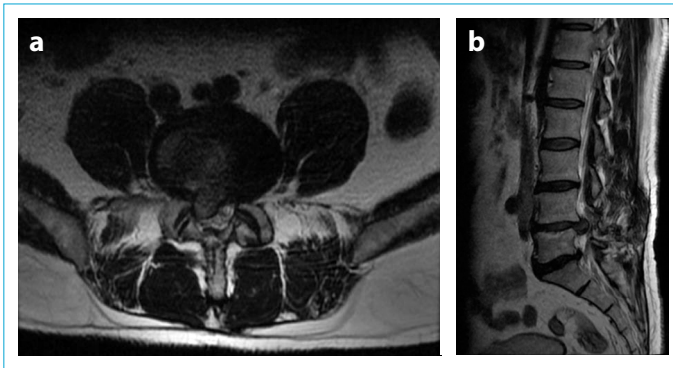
Male, 51 years old, relapsed 2 years after lumbar microdiscectomy for L4-5 right paracentral herniation. (a, b) T2 axial and sagittal MR images showing L4-5 right paracentral herniation and laminectomy defect on the right.
